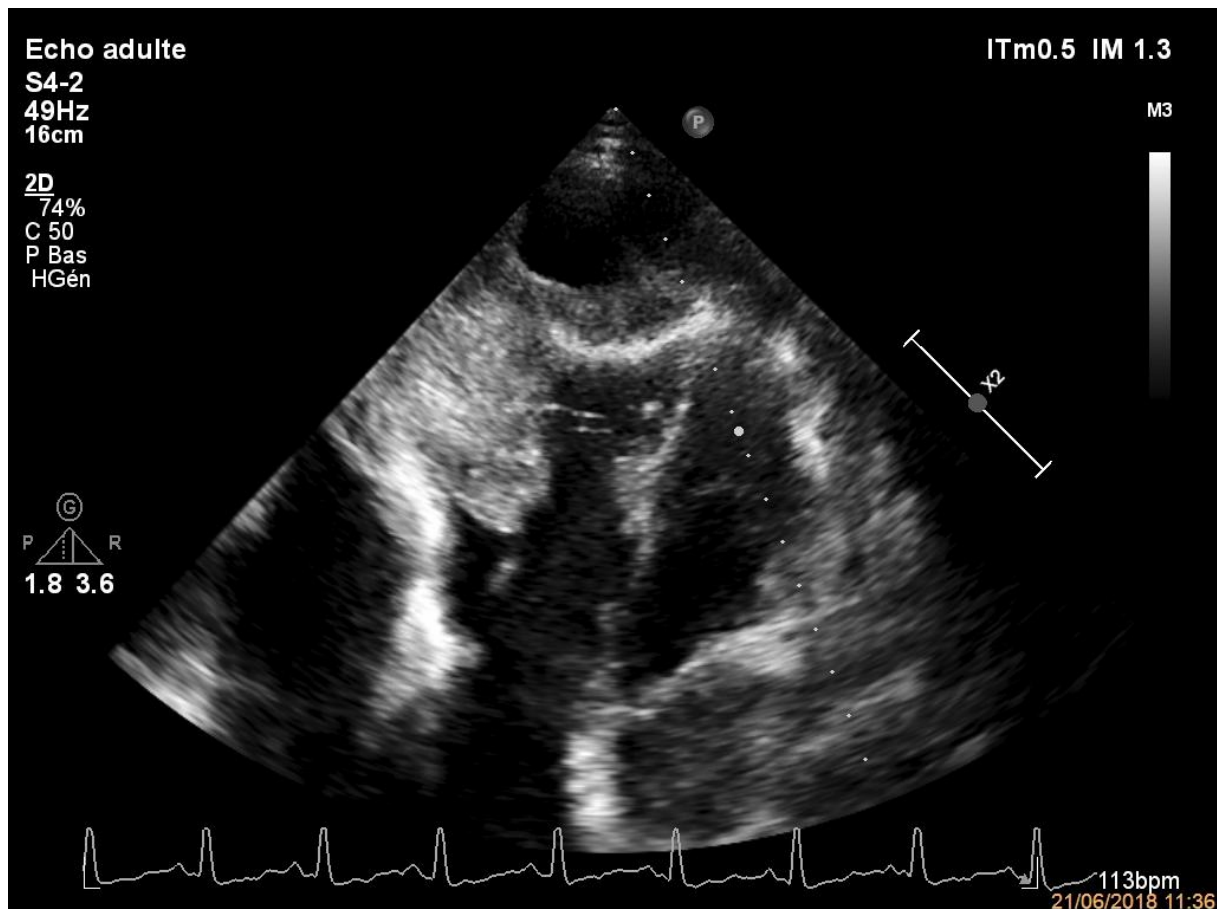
Transthoracic echocardiography (TTE),4-chamber view reveals irregular myocardial mass measuring 48× 28 cm, occupying large percentage of right ventricle with a large amount of circumferential pericardial effusion.
